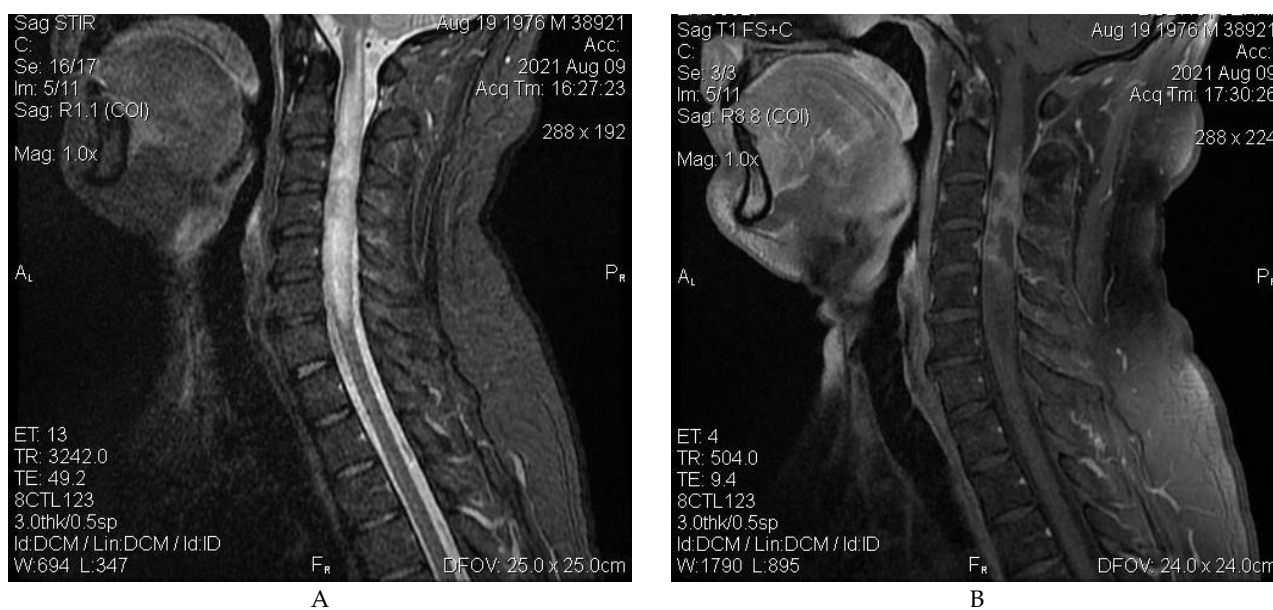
MRI of the patient's cervical spinal cord, August 9, 2021: a) sagittal sections in T2 weighted images; B) sagittal sections in T1 weighted images with contrast. The damaged area in the spinal cord at the level C1- C7 vertebrae with spread to the brain stem
